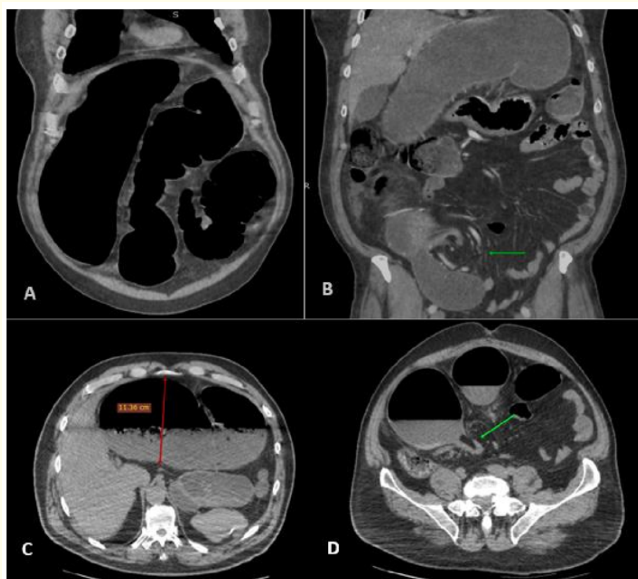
Abdominal-pelvic CT scan with contrast injection in portal time, coronal (A and B) and axial (C and D) slices showing: a sigmoid colon extending cephalad to the transverse colon and overlapping the liver (A), whirlpool sign (arrow) with twisting of the sigmoid vessels (B), colonic distension with hydroaerobic levels (C), transition zone with abrupt reduction in bowel caliber realizing the beak sign (arrow) (D).
